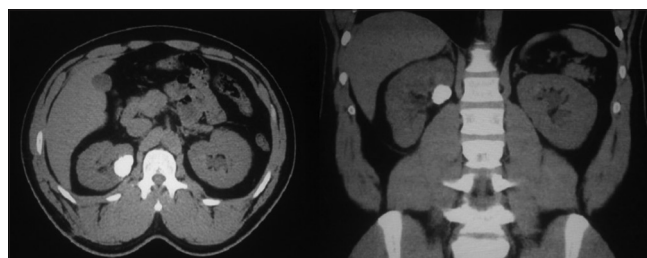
Computed tomography urography scan showing renal calculi in a closed diverticulum
